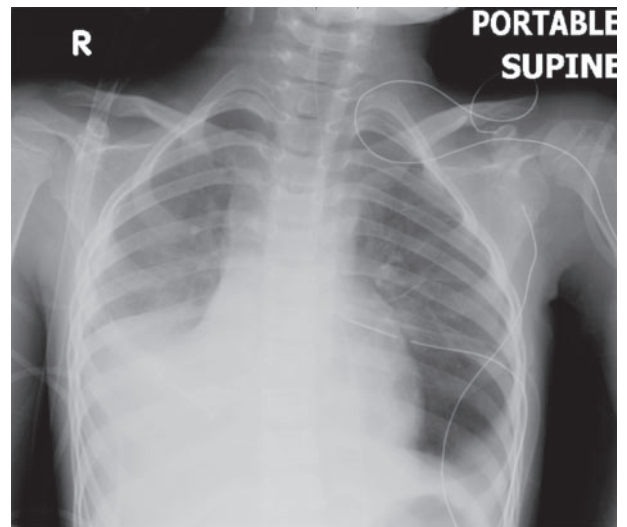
Chest radiograph showing resolving left pneumothorax after chest drain insertion.
